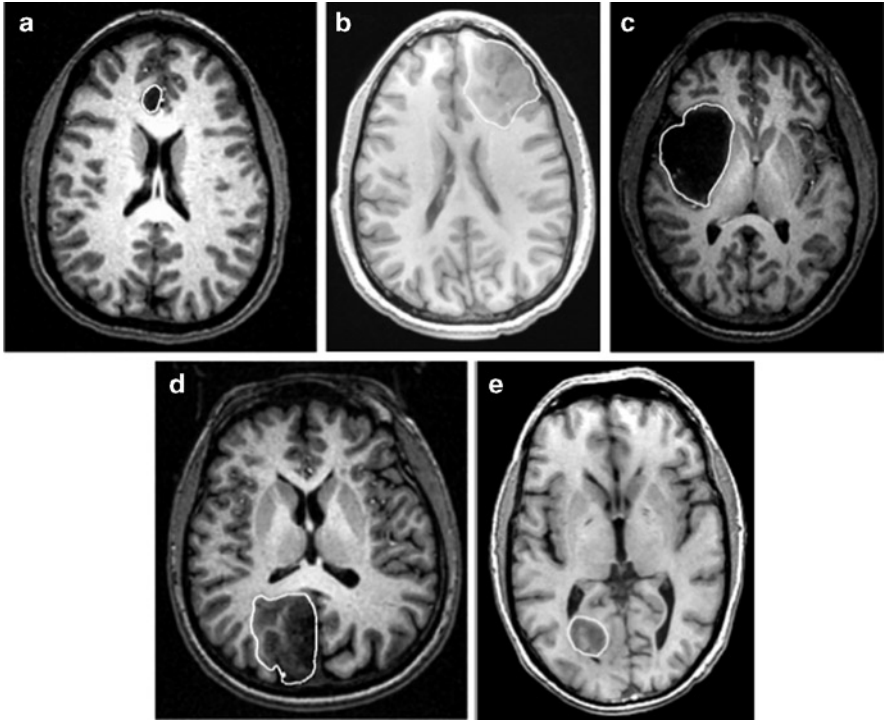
Pre-operative T1 MRI showing tumor location in five craniotomy cases analyzed in this study. *White lines* indicate the tumor segmentations
